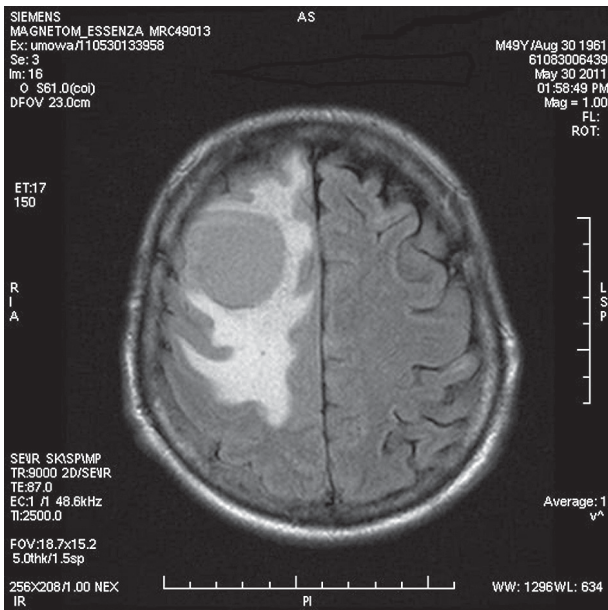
MRI scan – right frontal lobe tumor surrounded by edema
